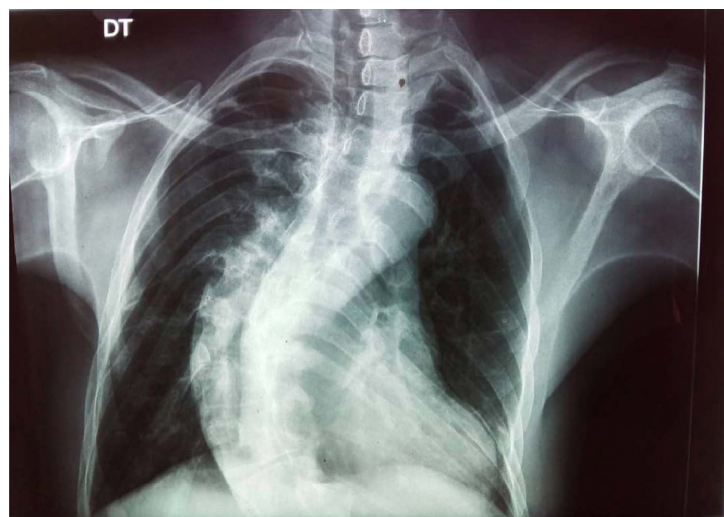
Frontal chest radiograph: disruption of the anatomical configuration of the heart; cardiomegaly (TCR = 58%); very wide and uncoiled aorta kyphoscoliosis.
